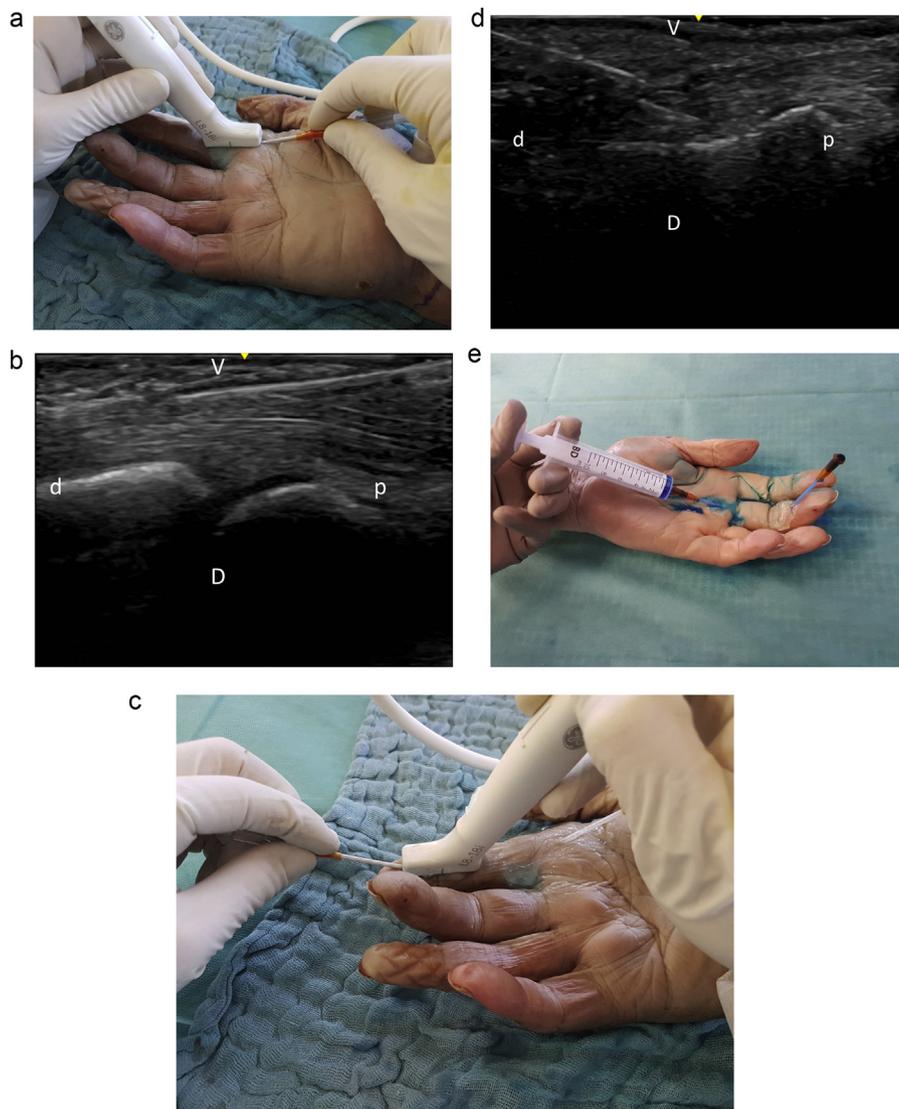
Minimally invasive technique for flexor tendon sheath lavage. Ultrasound-guided introduction of the proximal catheter (A). Ultrasound view of the introduction of the proximal catheter (B). Ultrasound-guided introduction of the distal catheter (C). Ultrasound view of the introduction of the distal catheter (D). Methylene-blue colored saline solution exiting the distal catheter. V: volar; D: dorsal; P: proximal; D: distal
